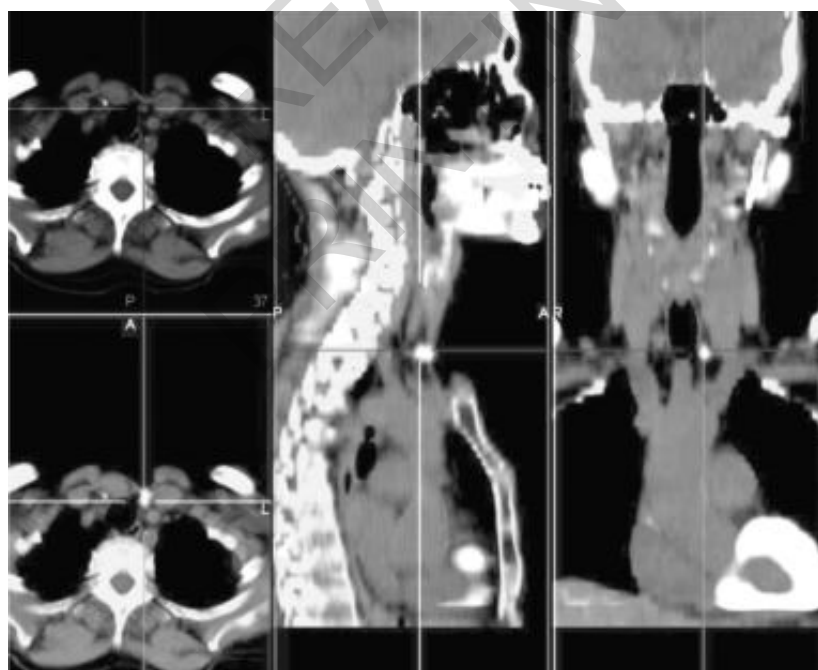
99 mTC-MIBI, SPECT CT: Left inferior parathyroid adenoma.
